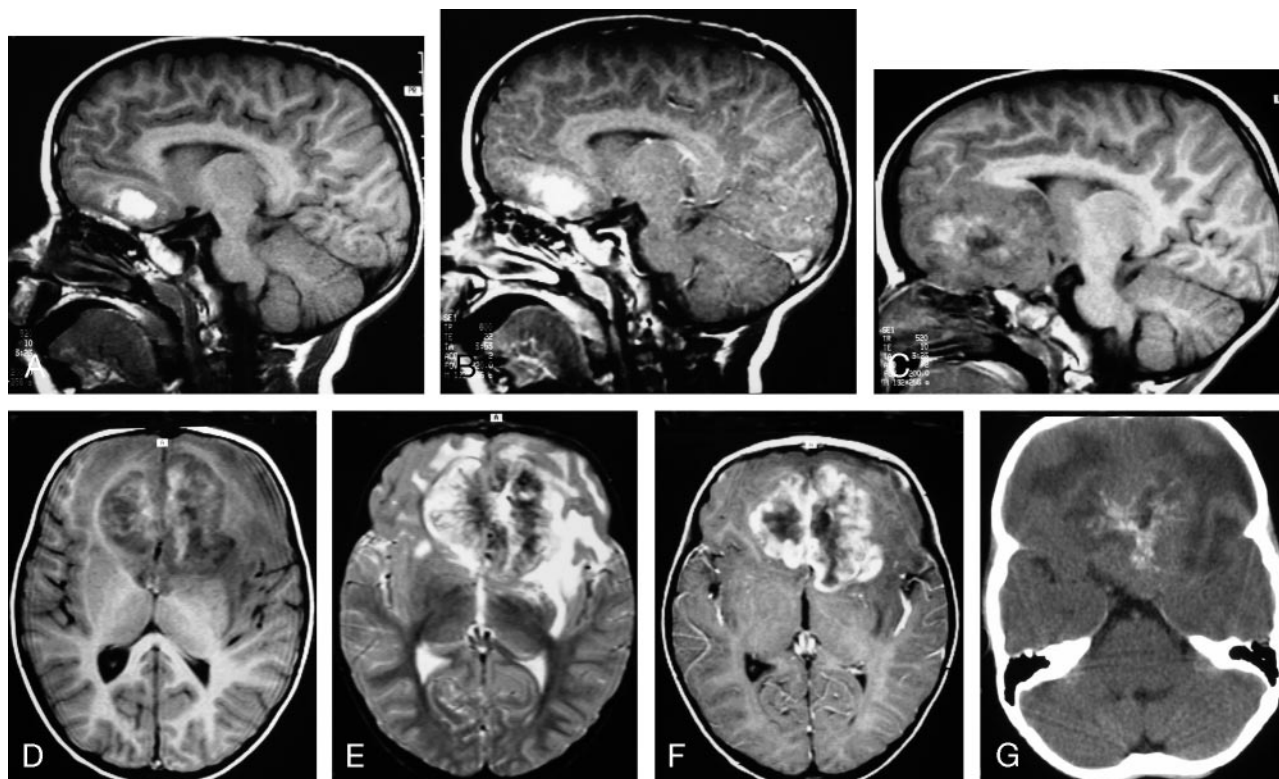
MR images of 3.4-year-old boy with a hemorrhagic AT/RT in the frontal lobe.
